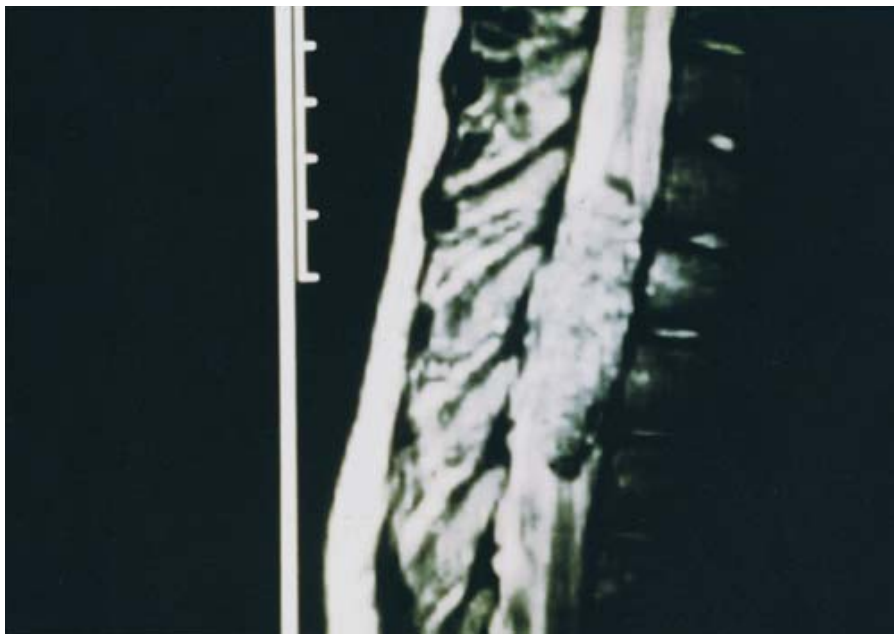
An intraspinal cavernous vascular malformation at the level of the T2 through T5 vertebrae (magnetic resonance imaging, T2-weighted sagittal image).
